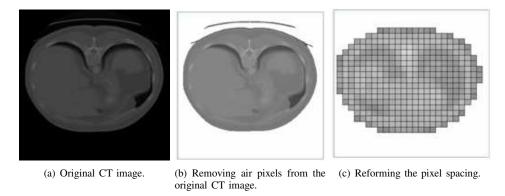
Example images for demonstrating filters which convert a original CT image to suitable format for making geometry.
